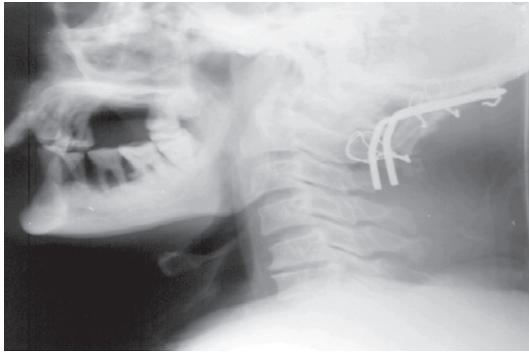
Post op X-Rays of case 1 showing good positioning of the implant.
